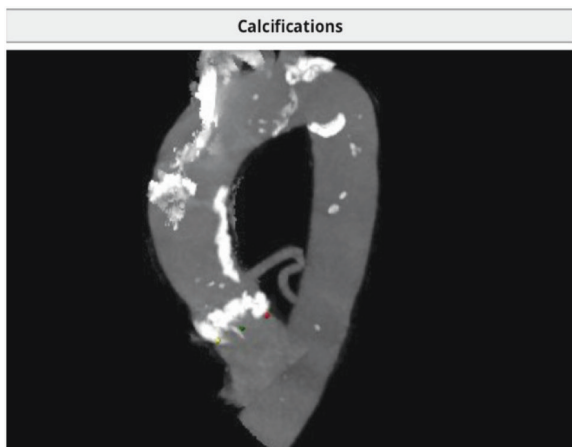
CT, porcelain aorta, patient No 1
